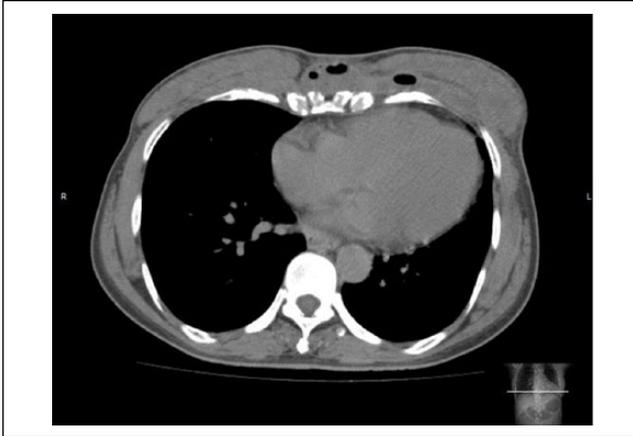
Coronal computed tomography image showing large air pocket superficial to the sternum and the overall heterogeneous appearance of the breasts.
